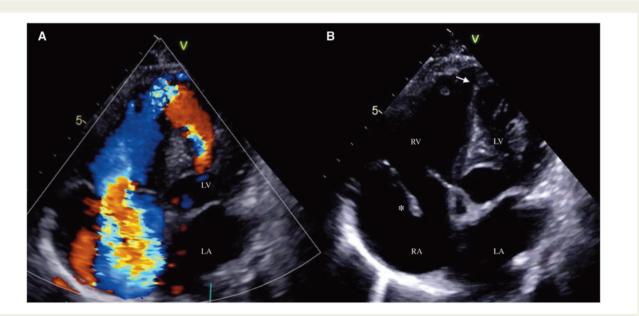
Figure I (A) Colour-Doppler showing severe tricuspid regurgitation and bidirectional shunt flow via the ventricular septal perforation (white arrow). (B) Four-chamber view showing the anterior tricuspid leaflet (*) is flail due to papillary muscle rupture as a complication of acute anteroseptal infarction. LA, left atrium; LV, left ventricle; RA, right atrium; RV, right ventricle.
